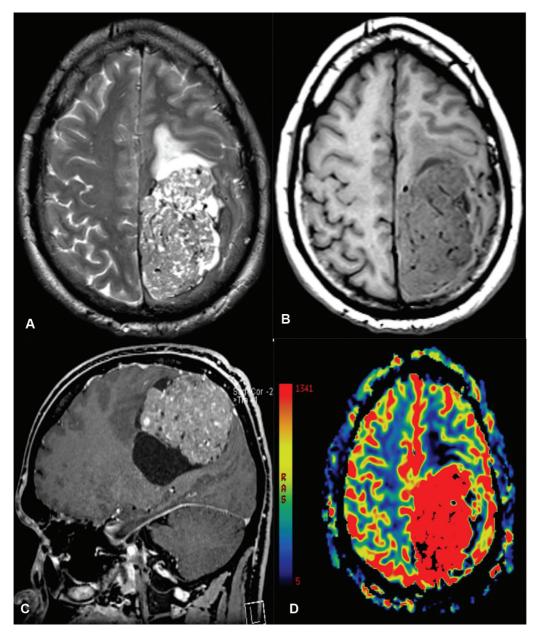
Axial T2-weighted (A), axial T1-weighted precontrast (B) and sagittal T1- weighted postcontrast (C) Magnetic resonance imaging (MRI) shows a large, solid-cystic extra-axial lesion in the left parieto-occipital region, presenting accentuated vascularization and heterogeneous contrast enhancement. Perfusion MRI (D) exhibits marked increase in the relative cerebral blood volume in relation to the contralateral normal white matter.
